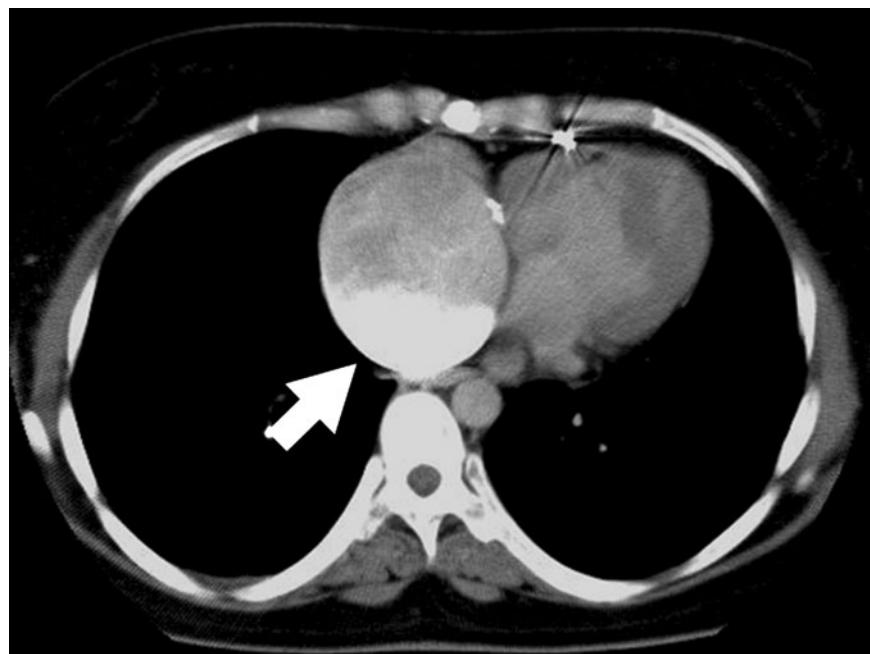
Preoperative computed tomography shows marked accumulation of contrast medium (arrow) in the dorsal portion of a giant right atrium
